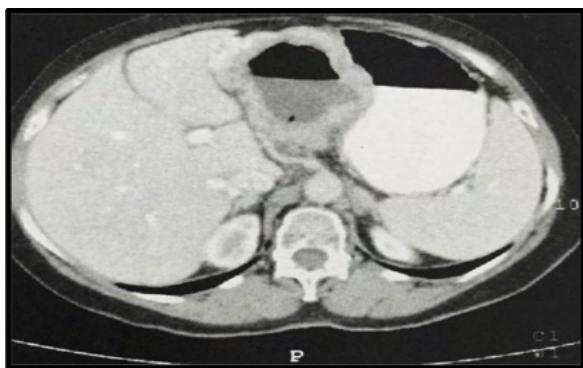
Computed tomography of the abdomen showing a tumor contiguous to the stomach with the presence of an air-fluid level partially rejecting the left hepatic lobe.
